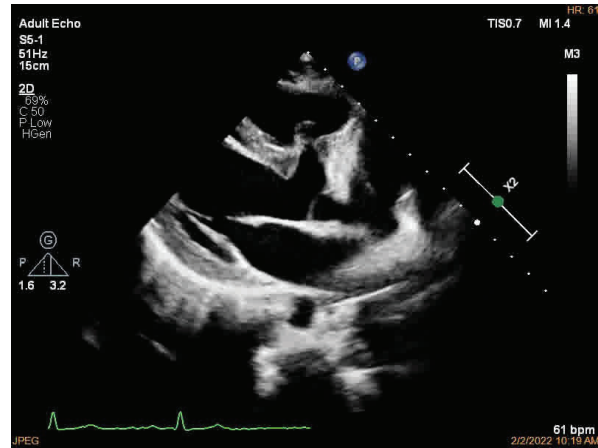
The parasternal long axis view (PLAX).
